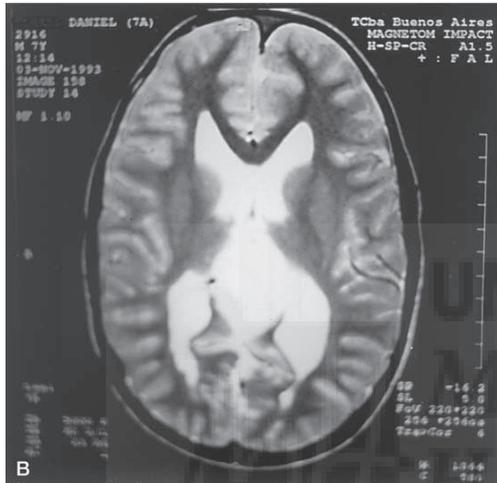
(A) Magnetic resonance  $T_1$ -weighted image ( $TR = 509$  ms,  $TE = 15$  ms) was obtained for the initial diagnostic determination of a quadrigeminal arachnoid cyst in a 7-year-old male with amblyopia and papilledema. (B) Magnetic resonance  $T_2$ -weighted image ( $TR = 3,000$  ms,  $TE = 45$  ms) axial view, demonstrates associated hydrocephalus to the quadrigeminal arachnoid cyst. (C) Computed tomography scan, axial view, obtained 6 years after insertion of a ventricular shunt device, demonstrates resolution of the hydrocephalus and marked reduction of the quadrigeminal arachnoid cyst.
